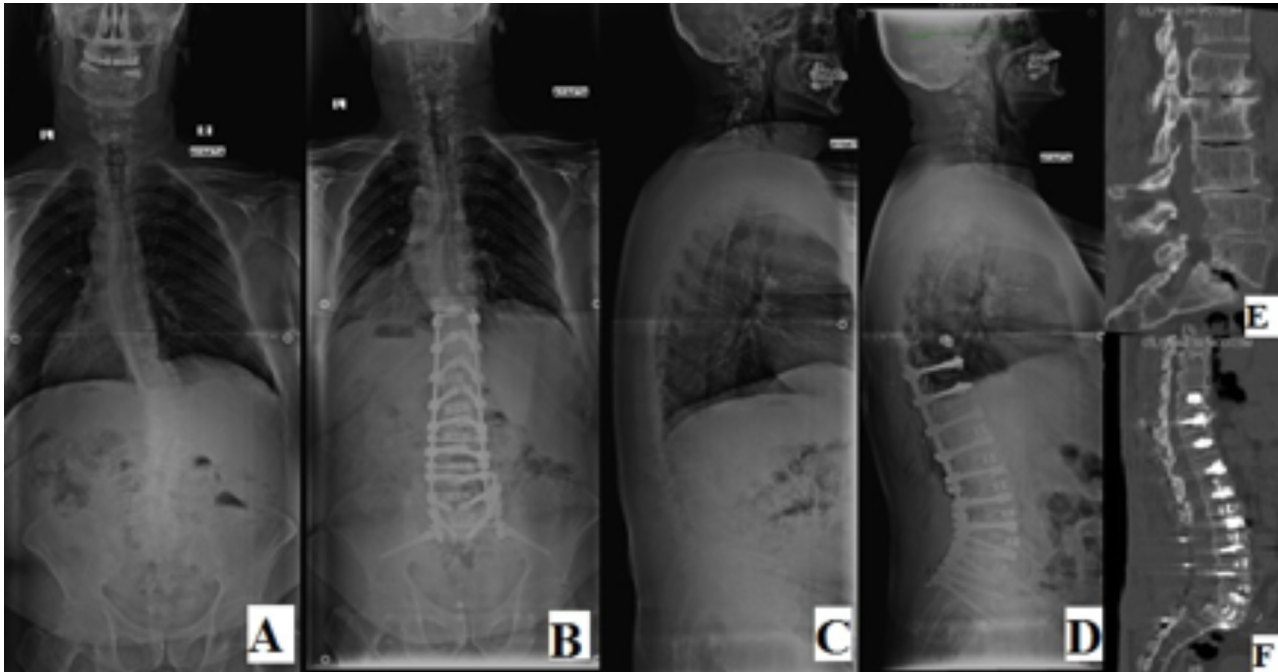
a) Preoperative standing anterior-posterior spine radiograph; b) Postoperative standing anterior-posterior spine radiograph; c) Preoperative standing lateral spine radiograph; d) Postoperative standing lateral spine radiograph; e) Preoperative computer tomography (CT_ sagittal scan; and f) Postoperative CT sagittal scan revealing screw loosening in the topmost level
